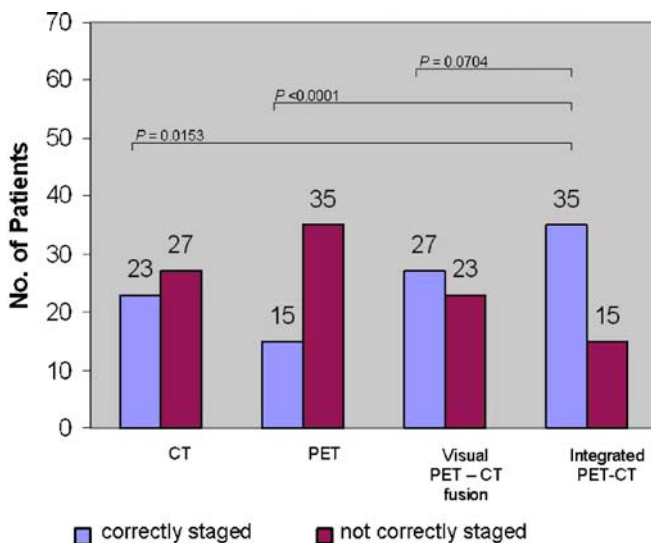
Accuracy of global TNM staging for integrated PET-CT compared with CT, PET and visually correlated PET-CT
